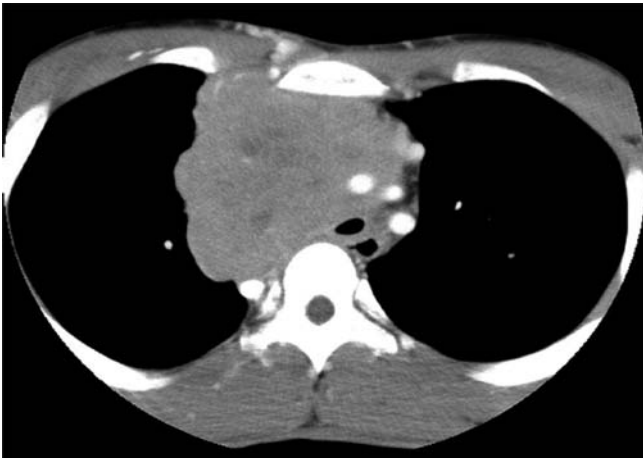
Pretreatment CT shows a solid soft tissue mass ($95 \times 75 \times 112$ mm) in the upper mediastinum, with leftward displacement of the trachea and complete obstruction of the superior vena cava.
